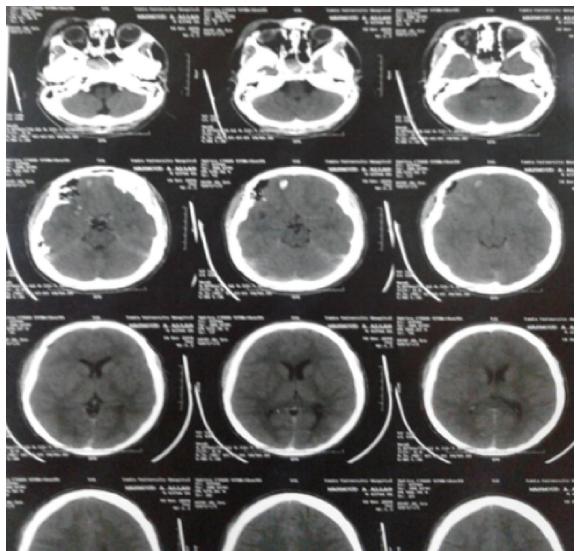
CT brain of case 2 after 48 hrs.
